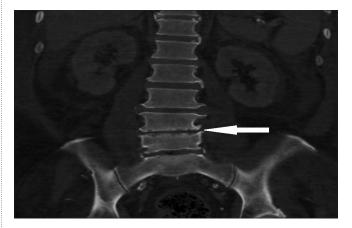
CT scan of the abdomen shows endplate irregularity and disc space narrowing of L4/5 suspicious of spondylitis (arrow).
